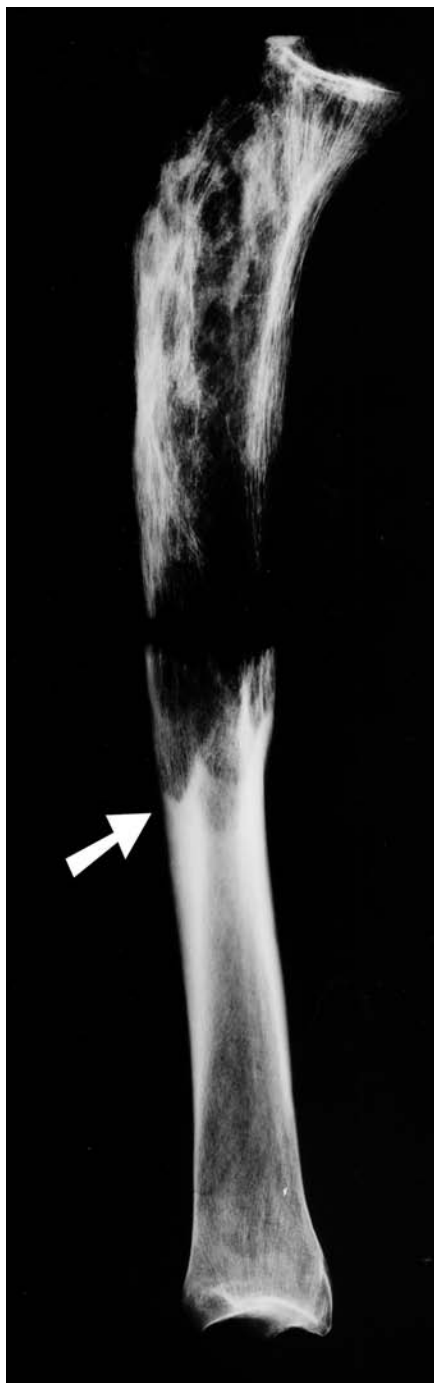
Lateral radiograph, left tibia, from an archaeological case of PDB. The diseased bone (proximal part of the tibia) has a mottled appearance and shows loss of cortico-medullary distinction. The demarcation between normal and abnormal bone (arrowed) is sharp, and the advancing front of diseased tissue is V-shaped
